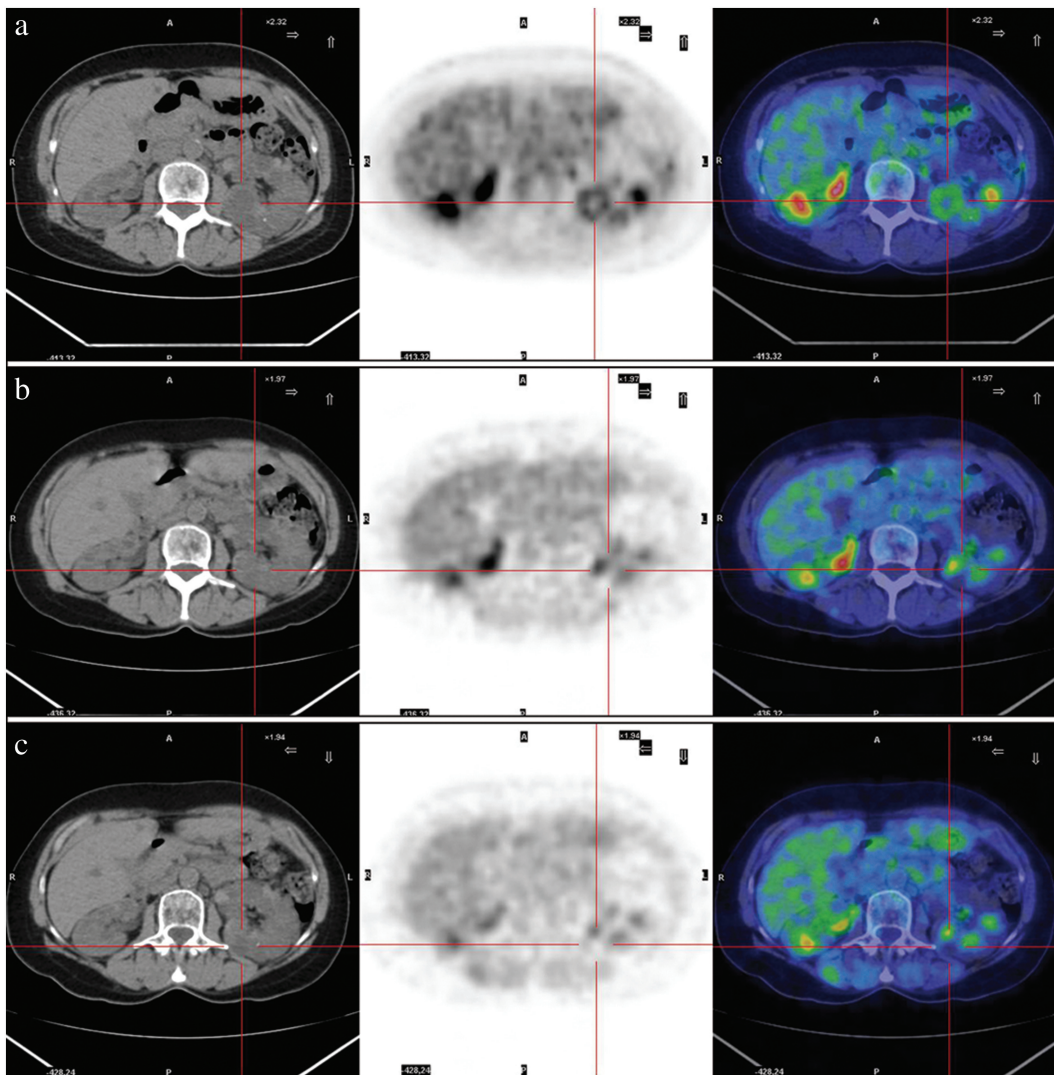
Transaxial images—in sequence, CT scan, PET scan and fusion image. (a) The first FDG-PET/CT scan done in the suspect of renal intracystic infection. PET image shows an intense FDG uptake at the level of a renal cyst (pointer), thus confirming the initial hypothesis. The pericystic pattern is typical. (b) The second FDG-PET/CT scan. PET image shows the presence of a faint pathological FDG uptake (head arrow). This finding is suggestive of a partial metabolic response to the antibiotic treatment. (c) The third FDG-PET/CT scan. PET image does not show pathological uptake (pointer). This finding is suggestive of a complete metabolic response to the antibiotic treatment. The intense background activity is due to the urinary elimination of FDG. Indeed, this was initially considered as a potential limit for kidney imaging by FDG-PET. However, the combination of the persistence of the positive circular area in the complicated cyst, located at the CT scan, and the fusion image allows the identification of the infection, in spite of the intense, but rapidly clearing, background activity.
